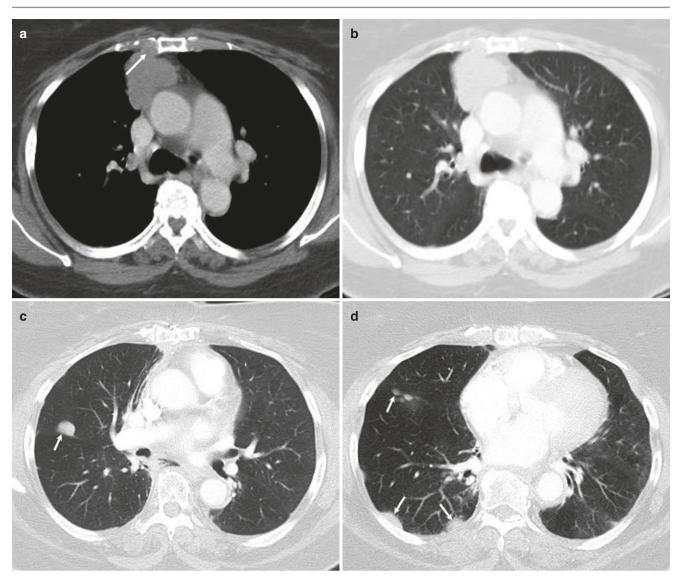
Invasive thymoma with recurrence. (a, b) Axial CT images show a lobulated mass in the prevascular space with focal invasion of chest wall (arrow). (c, d) Post-operative follow-up after 6 years—axial CT images show multiple pleural-based nodules (arrows)
